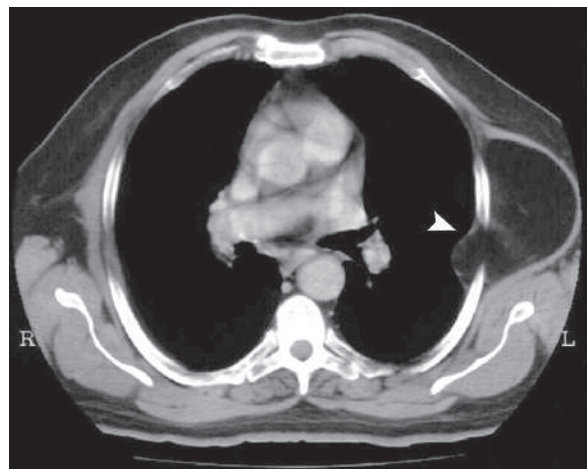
Axial nonenhanced chest CT shows left chest wall lipoma, seen as a typically well-circumscribed mass with fat-attenuation (arrowhead)
